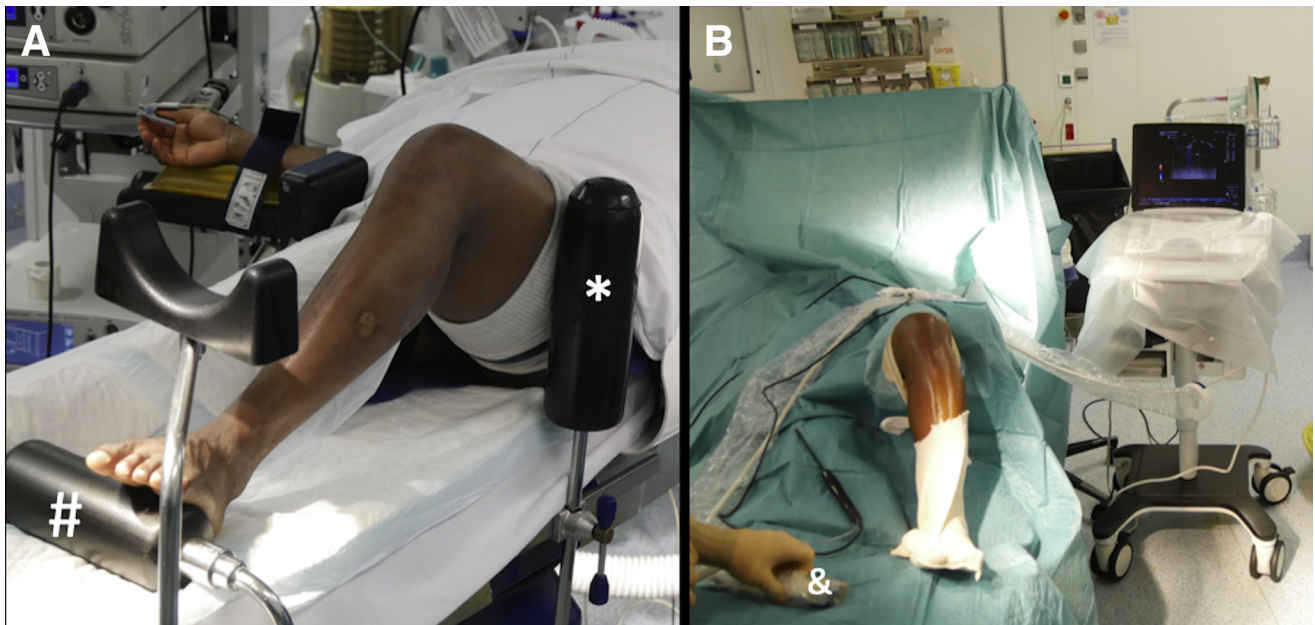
Patient setup. Left knee. (A) A lateral post (asterisk) just proximal to the knee prevents the hip from externally rotating, and a foot roll (hash tag) helps to keep the knee in 90° of flexion. (B) After surgical draping, a transparent sterile cover is placed over the ultrasound probe (ampersand) and workstation.
